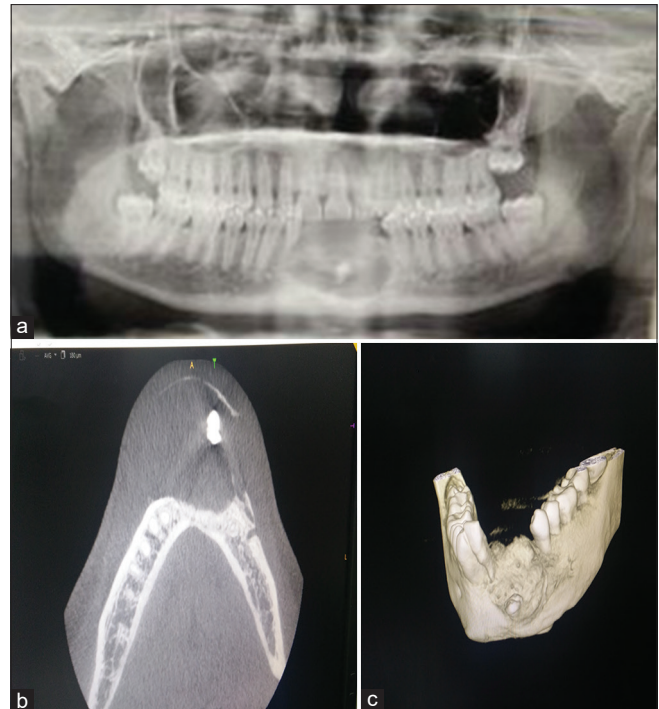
Radiograph of present case (a): Orthopantomogram showing well-defined unilocular radiolucency in the mandibular anterior region crossing the midline and root resorption of 42 along with a tooth-like radiopaque mass within the lesion (b): Cone-beam computed tomography showing round unilocular lesion with complete destruction of labial bony plate and irregular resorption front towards lingual side (c): Three-dimensional reconstruction of cone-beam computed tomography showing non uniform resorption of bone and a tooth-like calcification
